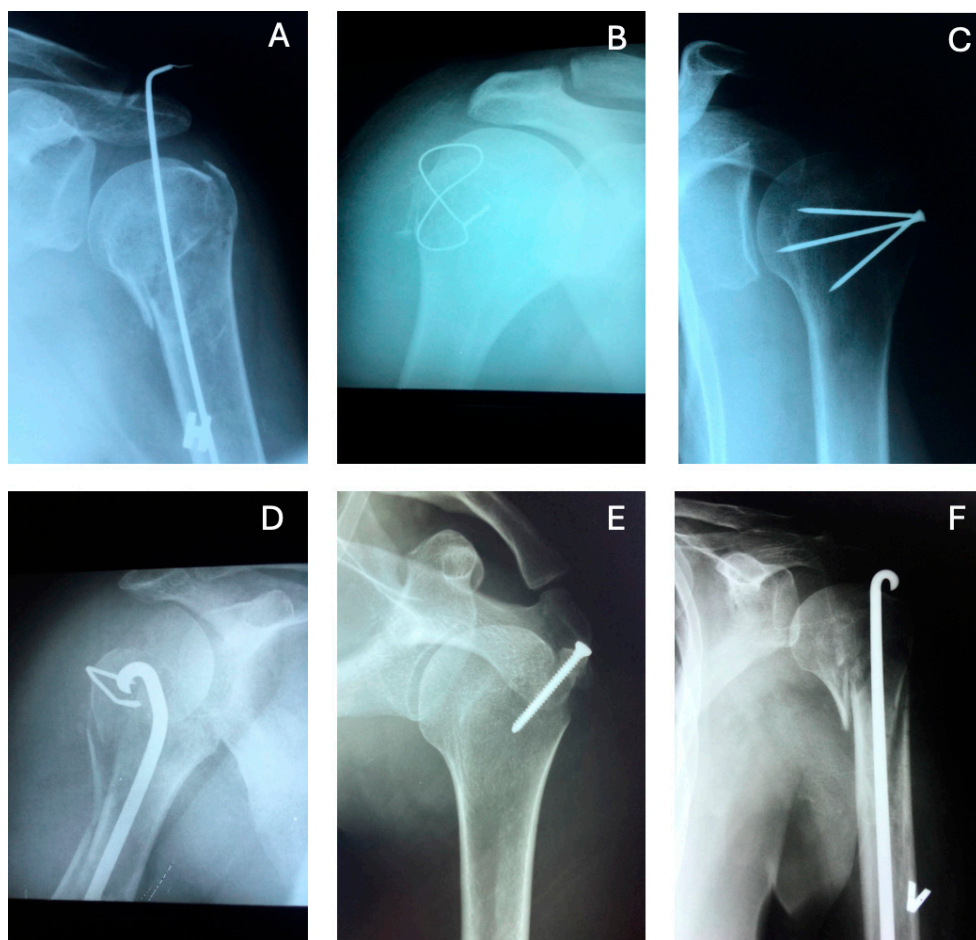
Treatment methods for PHF during the 20th century. A: Wire. B: Cerclage. C: Nails. D: Rushpin and bone-staple. E: Screw. F: Rushpin. All radiographs photographed by the author in the analogue radiology archive in Malmö, Sweden.
